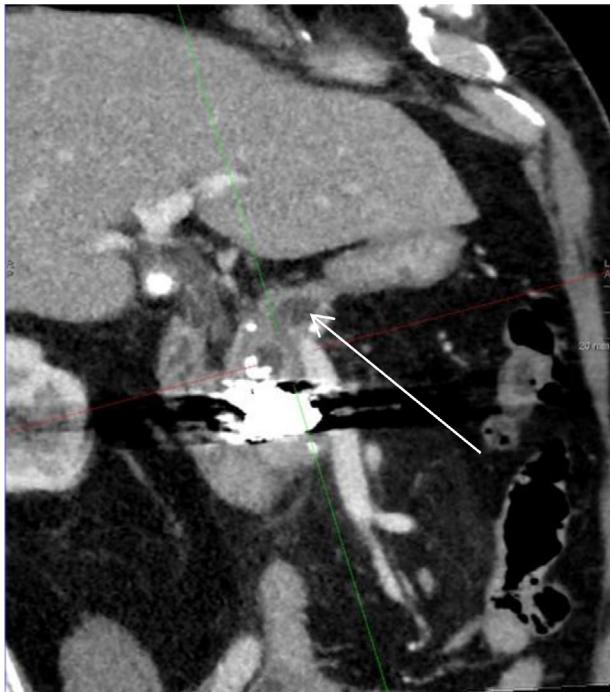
Coronal contrast-enhanced CT. Reduction of the pancreatic duct dilation (arrow).
